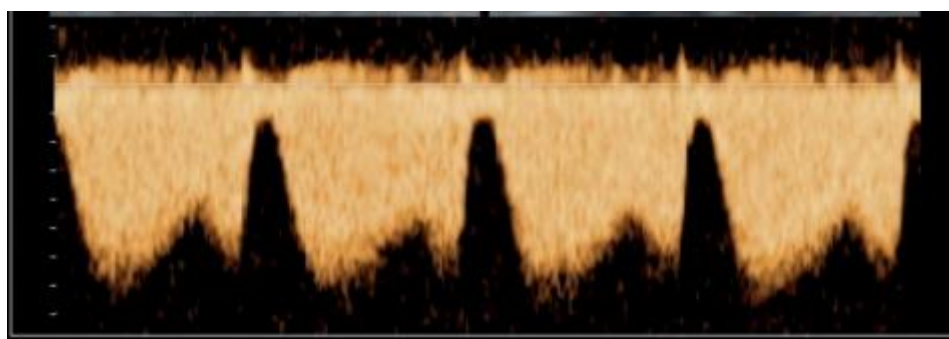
Normal doppler wave in ductus venosus[1].
